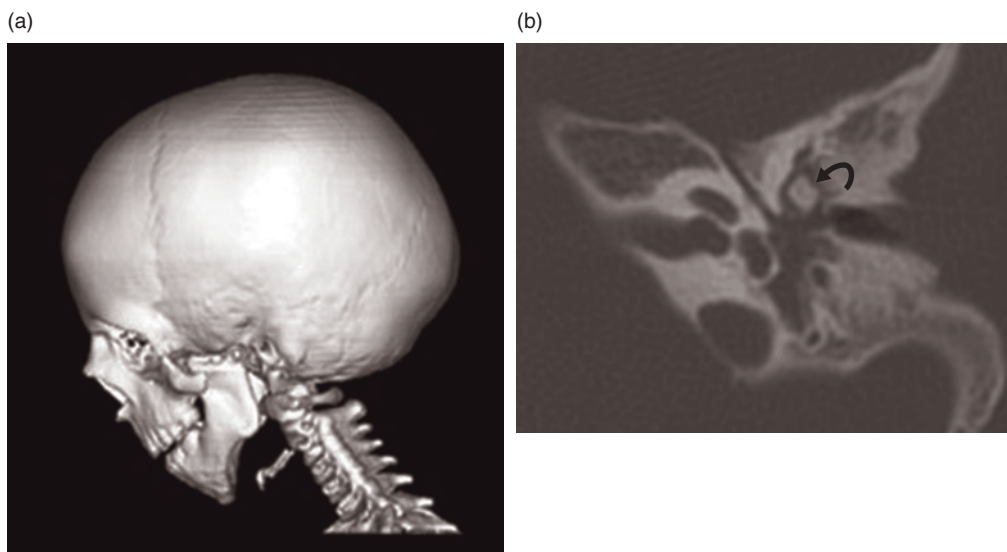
A 4-year-old male with Treacher-Collins syndrome. (a) Skull 3D-CT: incomplete zygomatic arch, mandibular hypoplasia and condylar dysplasia, mastoid hypoplasia. (b) CT axial scan: stenosis of the external auditory canal, small tympanic cavity, fusion of the malleoincudal joint (arrow).
